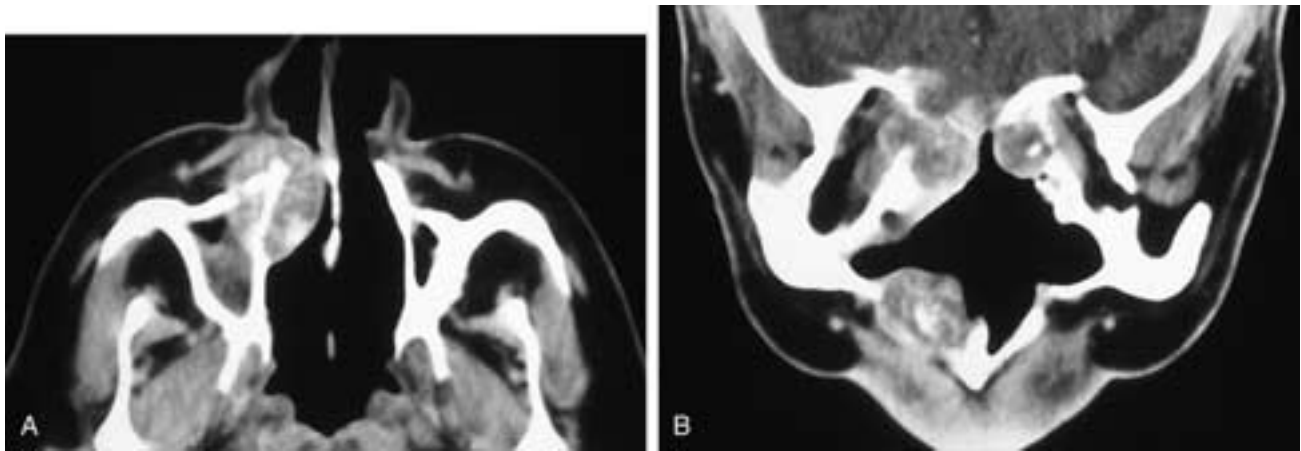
Axial (A) and coronal (B) CT scans on a patient who has had a craniofacial procedure. There are tumor nodules along the upper sinonasal cavity, in the right orbit, and along the right intracranial graft margin. There is also tumor in the right anterior maxilla. Speckled calcifications are seen within each tumor nodule. This patient had recurrent adenocarcinoma.
